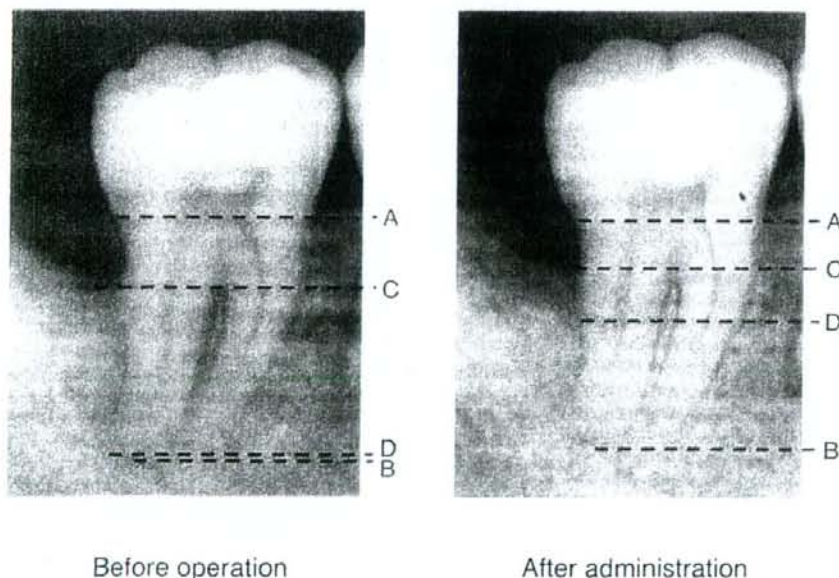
Measured points of alveolar bone height using standardized radiographs. Standardized dental radiographs taken before and after FGF-2 administration in one subject (a 29-year-old man) given 0.3% FGF-2. Points A, B, C and D represent the cemento-enamel junction, apex, remaining alveolar bone crest and bottom of the bone defect, respectively. The examiners measured tooth axis heights between Points A and B, Points A and C, and Points A and D on the X-ray for each patient. To adjust for slight errors due to imaging, measurements for 5 examiners were multiplied by A-B ratio of before to after administration to correct A-B, A-C and A-D after administration (adjusted A-B, A-C and A-D, respectively). Rate of increase in alveolar bone height was derived from the following calculation formula: $[(A-D \text{ before administration}) \cdot (\text{adjusted A-D after administration})] \div C-D \text{ before administration}$. On this radiography, C-D before administration, A-D before administration and, adjusted A-D after administration measured 9.00 mm, 12.80 mm and 5.93 mm, respectively. These values assigned to the above formula, we obtained the rate of increase in alveolar bone height as follows. The rate of increase in alveolar bone height (%) = $100(12.80 - 5.93)/9.00 = 76.35$. doi:10.1371/journal.pone.0002611.g002
